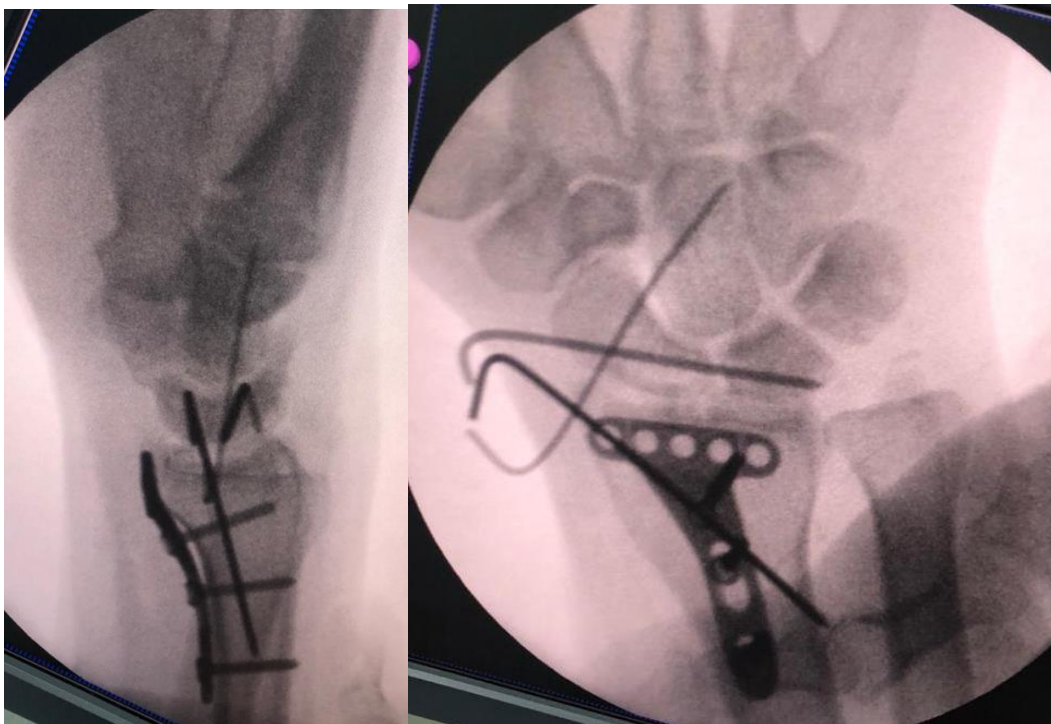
Postoperative wrist x-ray after reduction of volar fragment and fixation with volar plate in addition to volar ligament repair and scapholunate reduction and fixation
